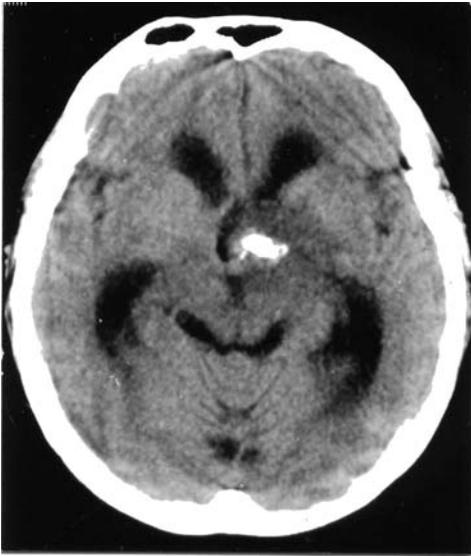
Preoperative CT scan. A rounded mass in the region of the third ventricle, slightly hyperdense with of calcification obstructing the foramina of Monro is seen. Surrounding brain edema and obstructive hydrocephalus can also be appreciated.*
